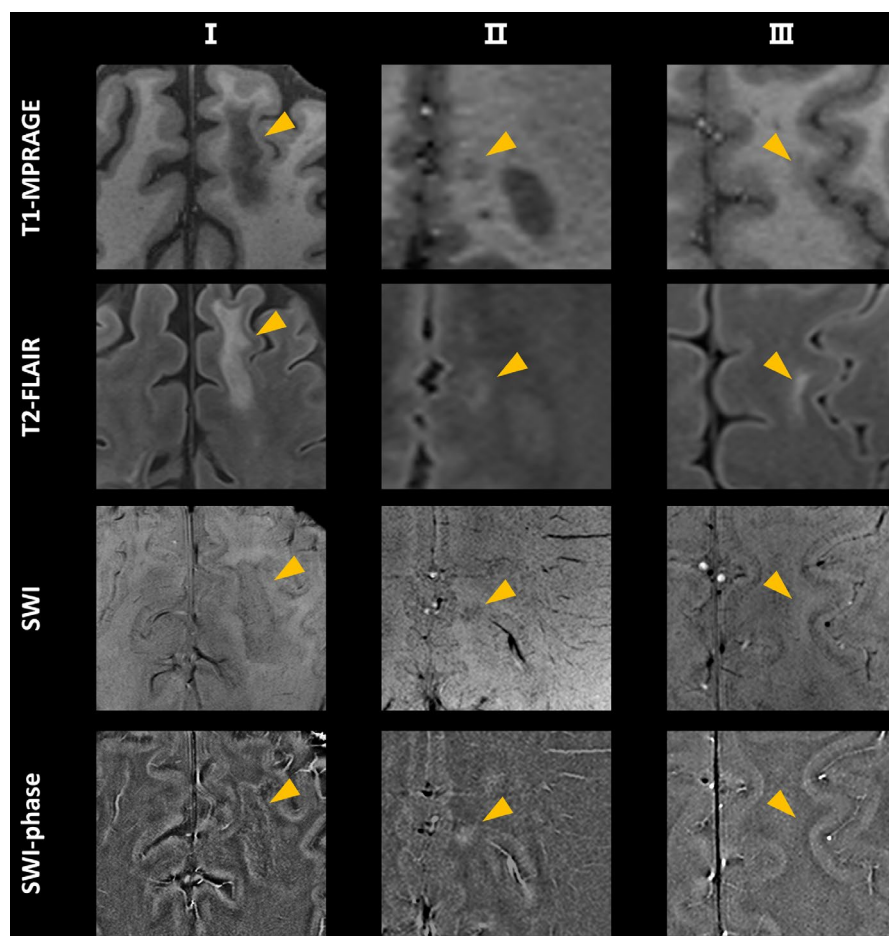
Lesion characteristics on SWI in MOGAD patients under 7T MRI. This figure shows three different types of morphological and phase changes of MOGAD lesions obtained from T1-MPRAGE, T2-FLAIR, SWI, and SWI-phase MRI. Lesions are marked by arrowheads. The top row shows lesions on T1-MPRAGE MRI. The other rows demonstrate the same lesion on T2-FLAIR, SWI, and SWI-phase MRI, respectively. Three lesion subtypes were identified; Type I: A subcortical white matter lesion with paramagnetic irregular border and hypointense signal on SWI. Type II: A white matter lesion with paramagnetic nodule and hypointense signal on SWI. Type III: A juxtacortical white matter lesion without phase changes and isointense signals on SWI.
